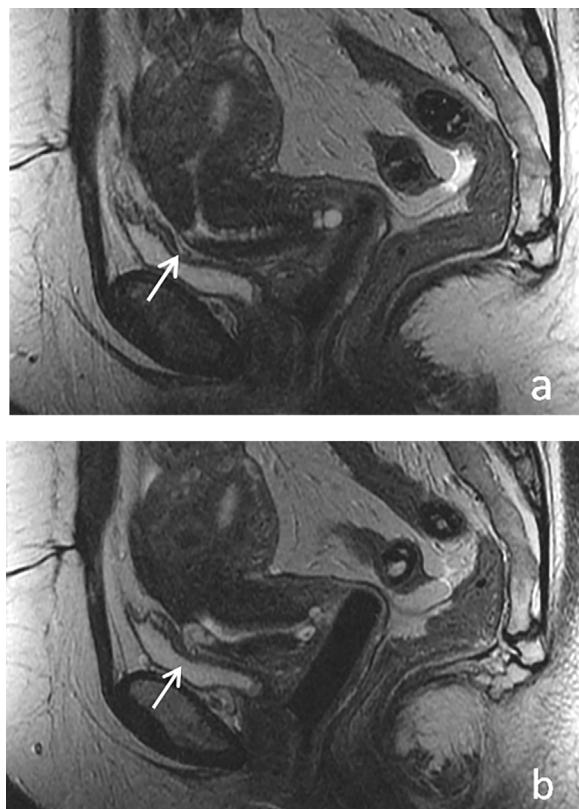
Pelvic adhesions after cesarean delivery.- 39 y.o. patient with 2 prior cesarean deliveries and 2 curettages presenting with pain during miction. The sagittal (a, b) T2-W MR images show the uterine dehiscence at the level of the prior cesarean scar. Note fine adhesions (white arrow) between the uterine dehiscence and the bladder dome. Symptoms released after surgical adhesiolysis.
